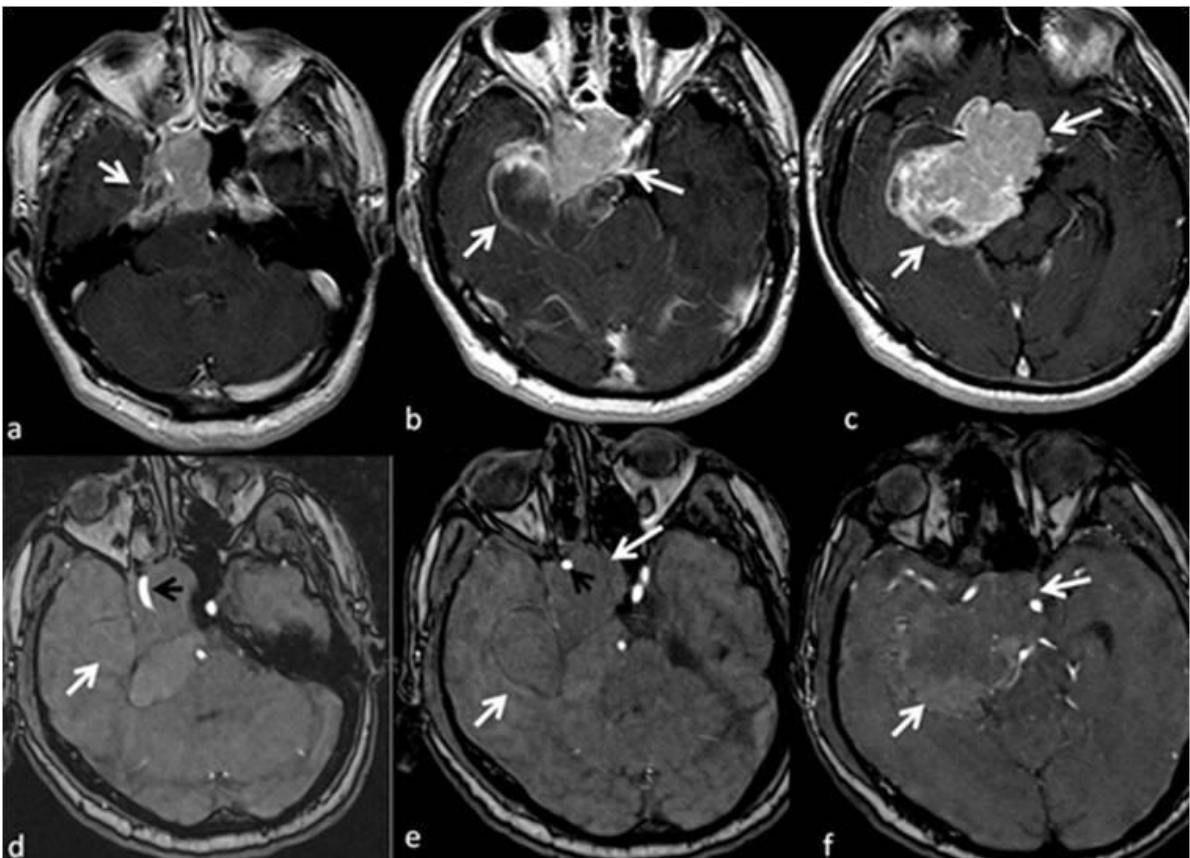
Post-contrast T1-weighted (a–c) and TOF MR angiography images (d–f) obtained in 2019, showing a giant mass (white arrows) completely encircling the cavernous and supraclinoid segments of the internal carotid artery and invading the right cavernous sinus (black arrow).
